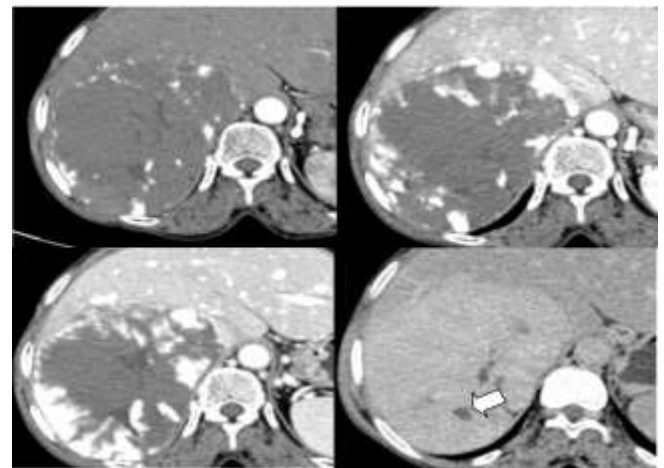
Peripheral enhancing lesion with Centripetal Filling :Arterial (Top Left), Portal venous (Top right), Delayed(5 mins) and Delayed (10 mins) CT images obtained at the same level show a large mass in the right hepatic lobe. There is peripheral nodular puddling of contrast material which matches the blood pool as it fills in the lesion through the interstices. Delayed phase CT images show progressive centripetal enhancement of the mass with a central area of low attenuation (arrow), a finding compatible with a fibrous scar.
